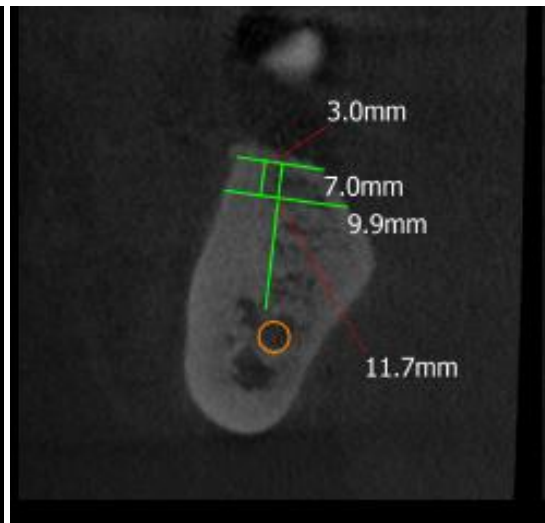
CBCT 3 mm below crest at 6 months
